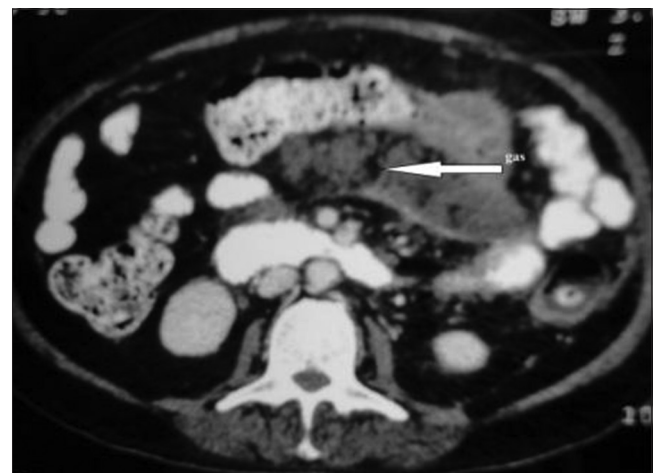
Computed tomography scan of abdomen showing gas formation in pancreas on day 21 of pancreatitis
